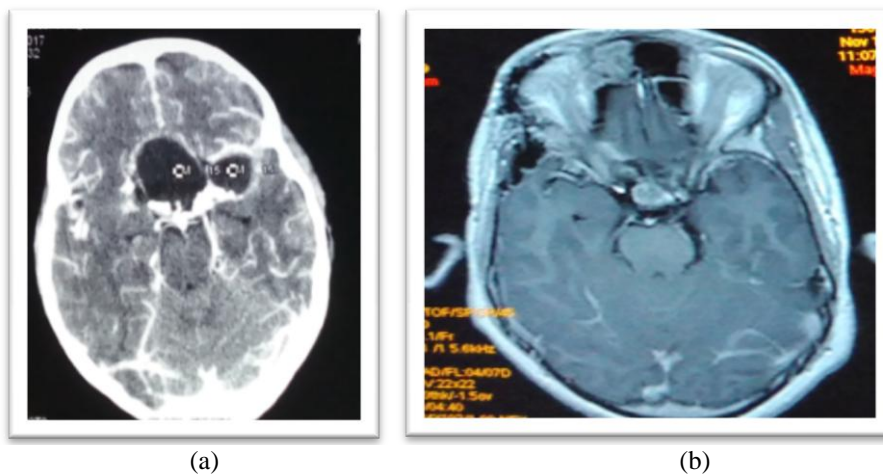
(a) CT Scan Brain: A cystic lesion in suprasellar cistern with peripheral calcification. Meningeal enhancement suggests meningitis. (b) shows T1 MRI image different patient showing hypointense lesion with peripheral enhancement in suprasellar cistern. This is a case of craniopharyngioma
